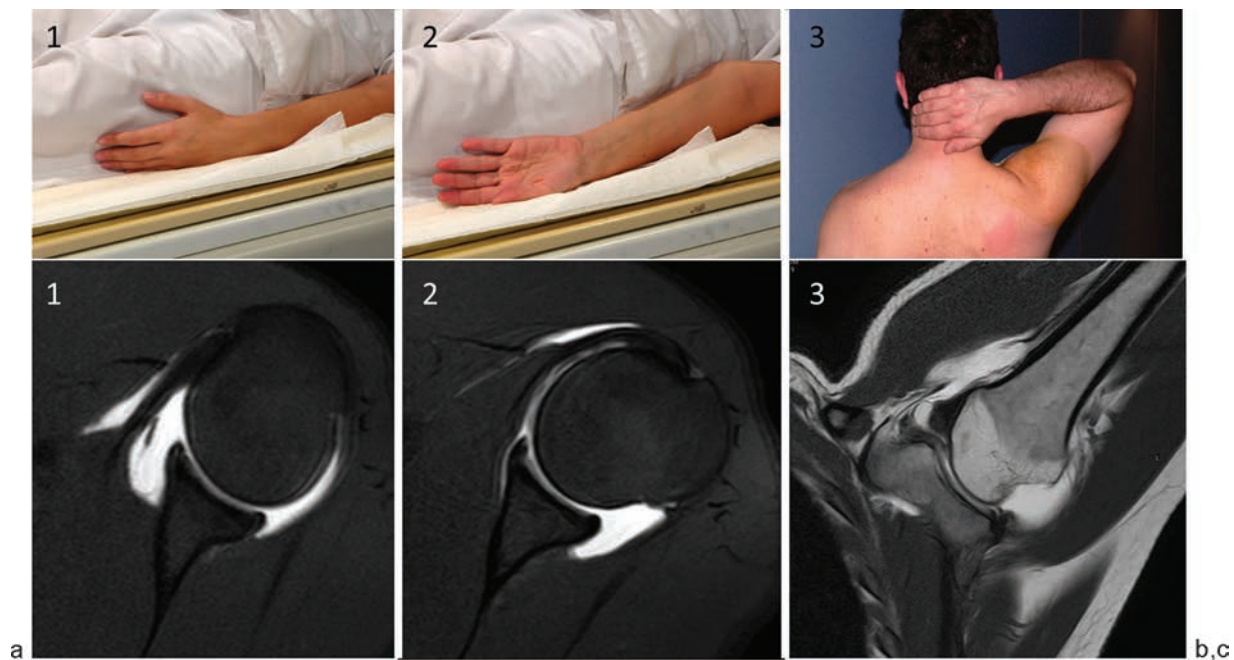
Different positions on MRI. (a) Neutral-internal rotation position. (b) Forced external rotation. (c) ABER. 1–3. Corresponding MR images.
